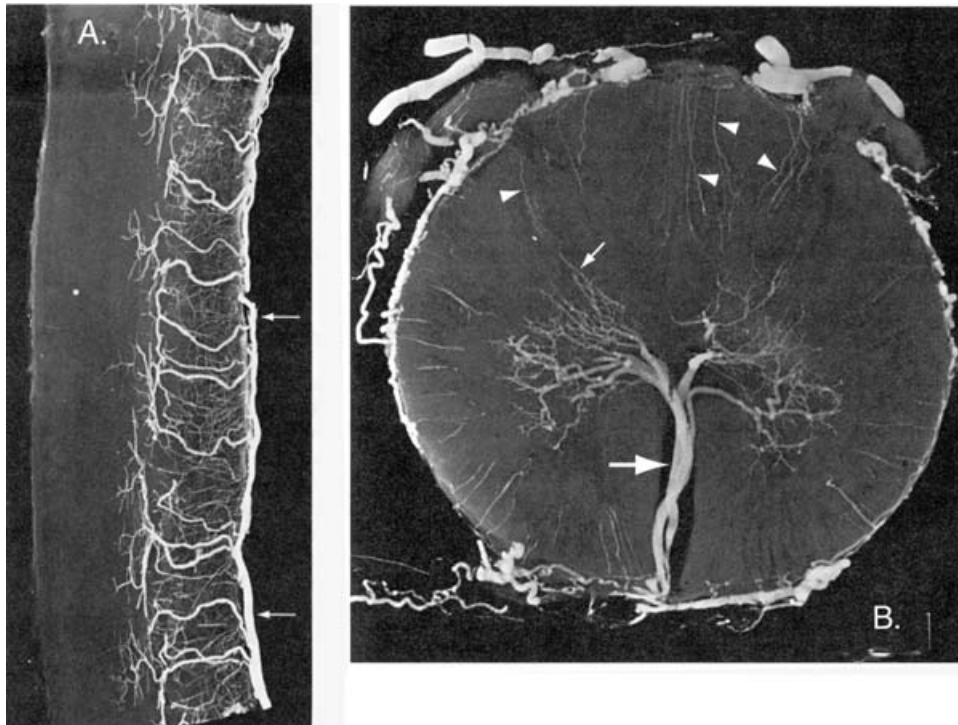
Spinal arteries after contrast injection into anterior spinal artery. The injection was done post-mortem, and then X-rayed after fixation and dissection. (Modified from Nolte, *The Human Brain*, 4th ed., © 1999, Mosby, St. Louis, figure 10-28, page 249.)
